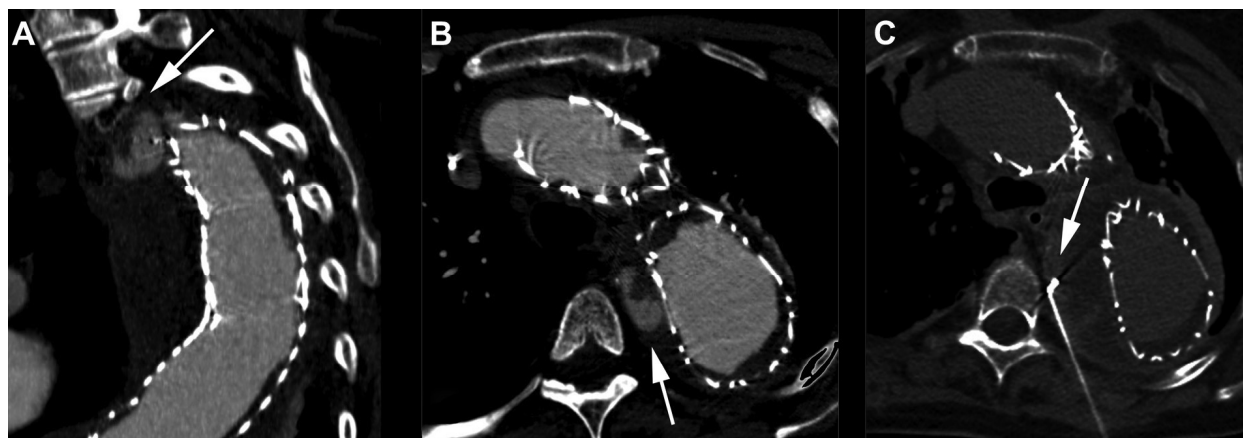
Axial image (A) and double-oblique multiplanar reconstruction (MPR) of computed tomographic angiography (CTA) (B) demonstrate a type II endoleak (ELII) originating from an intercostal artery (arrow). As shown in the axial image in (C) the EL was treated by computed tomography (CT)-guided embolization (patient no. 5; Table III).
